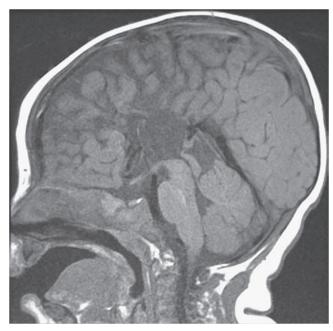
The magnetic resonance imaging (MRI) scan of the patient whose EEG was shown in the previous figure demonstrates absence of the corpus callosum. The next figure shows the MRI of an individual with an intact corpus callosum for comparison.
